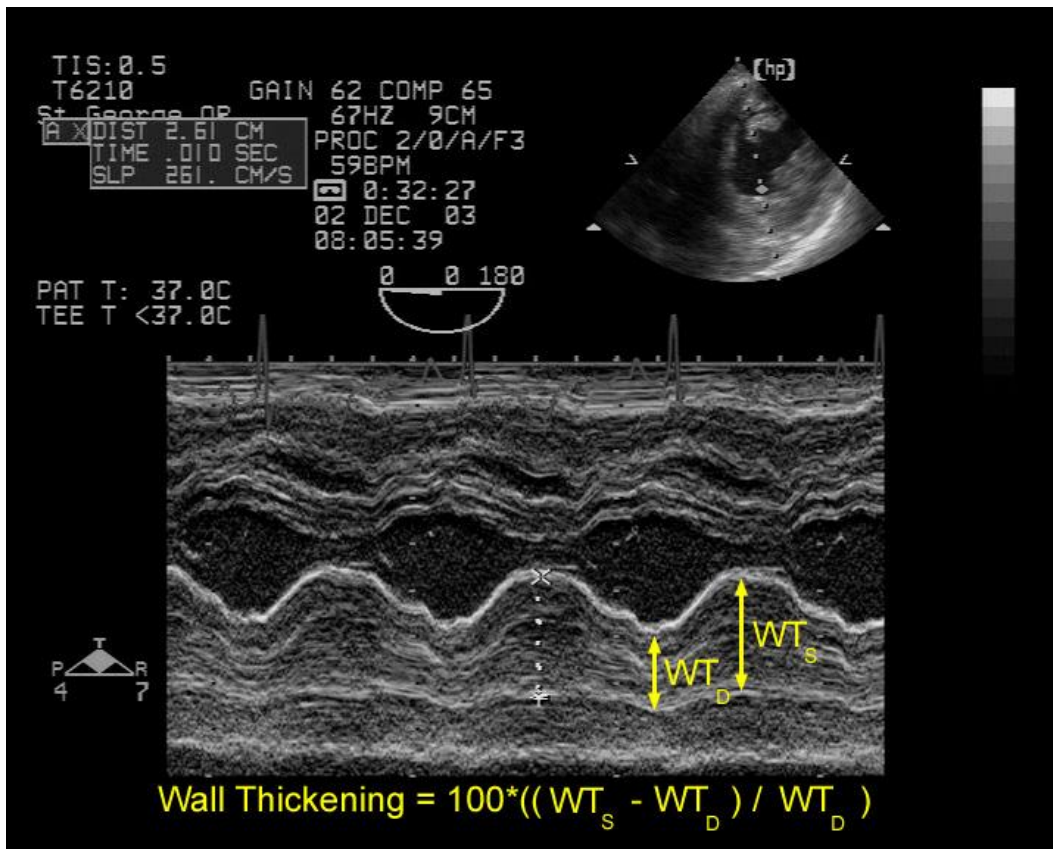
Example of estimation of wall thickening by echocardiography.
